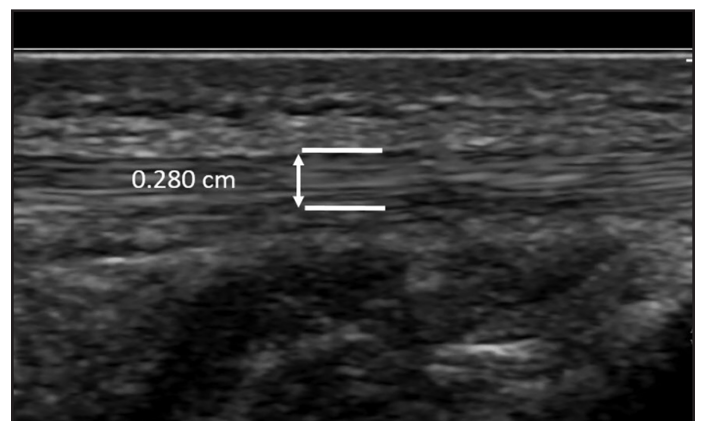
Sonographic Image of Athlete 1's Left Patellar Tendon (Posttest). Tendon thickness reduced to 0.280 cm from 0.391 cm at baseline.
